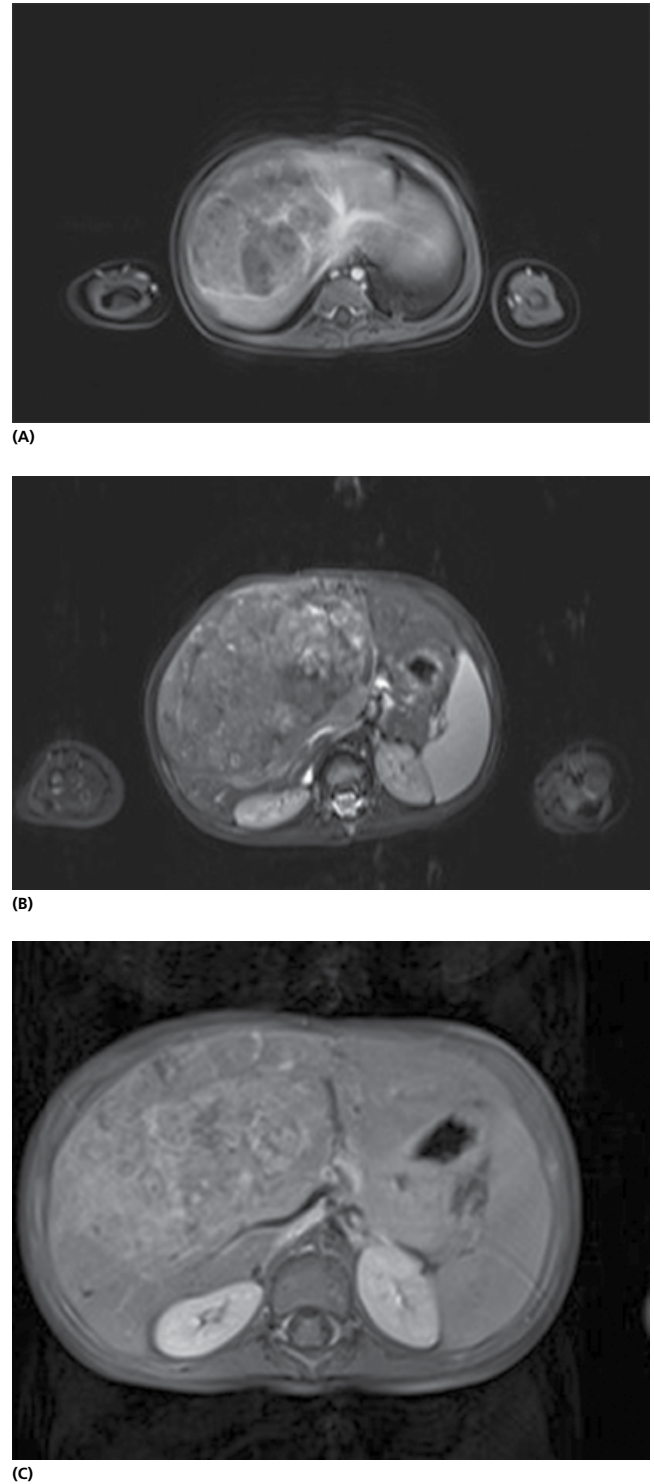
MRI scan of a PRETEXT III hepatoblastoma. (A) T1-weighted image: the tumor extends to the middle hepatic vein and confluence of all three hepatic veins. (B) T2 STIR image: the tumor extends to the bifurcation of the portal veins with the right portal vein closely applied to the medial border of the tumor. (C) Post chemotherapy image showing very little response and continuing tumor proximity to the portal veins.
